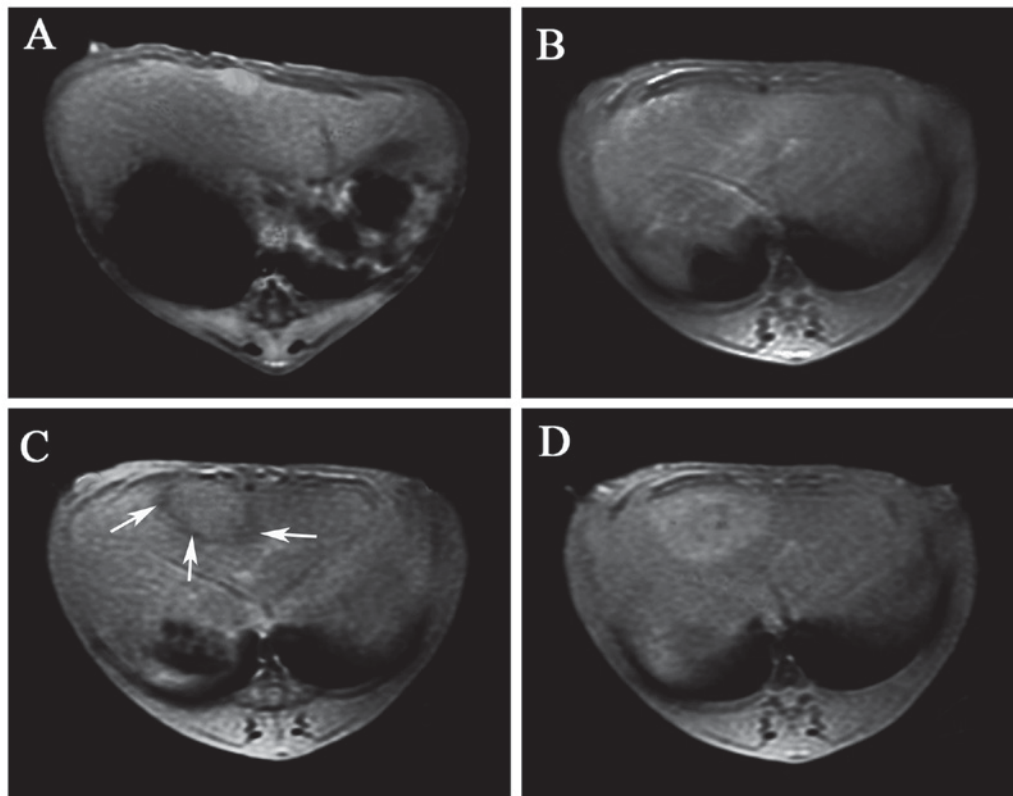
MRI of the liver tumor before and after transplantation of labeled MSCs. (A) The liver tumor was hyperintense on the T2*-weighted image prior to the administration of MSCs. (B) At 3 days after the injection of superparamagnetic iron oxide-labeled MSCs, MR imaging demonstrated heterogeneous hypointensity in the tumor, with an unclear demarcation. (C) At 7 days after transplantation, the MRI signal of the tumor reverted back to isointensity, whereas a hypointense ring was detected at the tumor border (white arrows). (D) At 14 days after transplantation, the hypointense ring disappeared, and the MRI signal recovered to the level observed prior to transplantation. MSCs, mesenchymal stem cells; MRI, magnetic resonance imaging.
